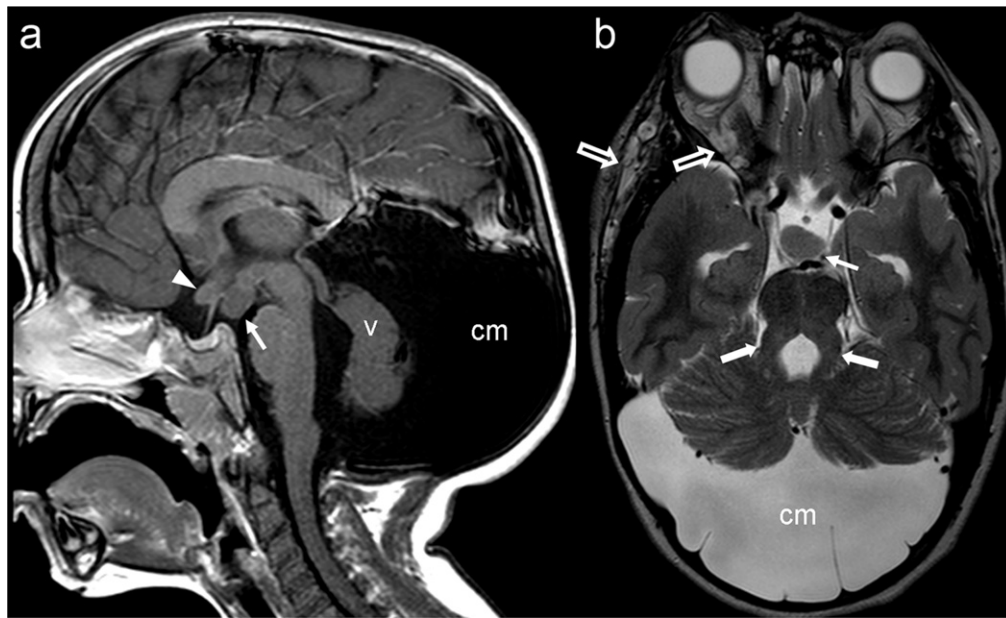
Varadi–Papp syndrome and coexistent Neurofibromatosis type 1. (A) Gd-enhanced sagittal T1-weighted image; (B) Axial T2-weighted image. Hypothalamic hamartoma attached to the floor of the third ventricle and projecting into the interpeduncular fossa (*thin arrow*, A, B). Pathologic thickening of the optic chiasm (*arrowhead*, A), without contrast enhancement, and small neurofibromas in the right orbit and temporal subcutaneous region (*open arrows*, B). Vermian hypoplasia (v), huge cystic dilatation of the cistern magna (cm) and molar tooth malformation (*thick arrows*, B).
